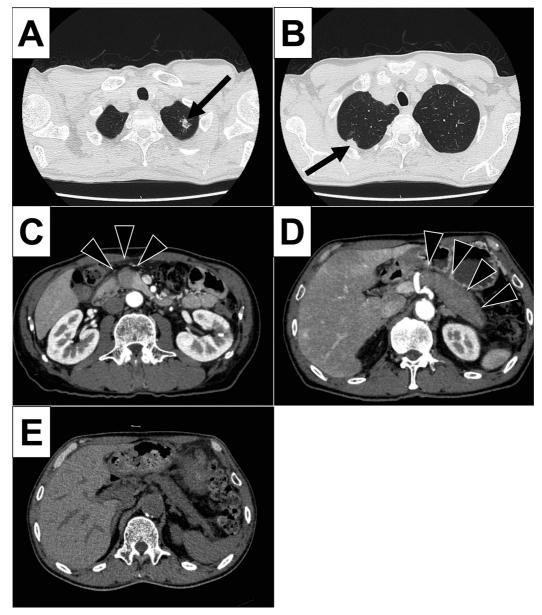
Findings of computed tomography.
